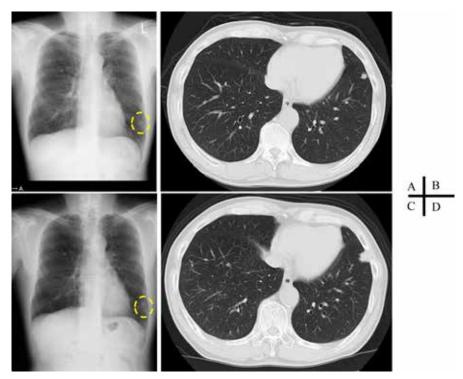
Chest radiography and computed tomography performed at 40 months before referral (A, B) and at the time of referral (C, D).
